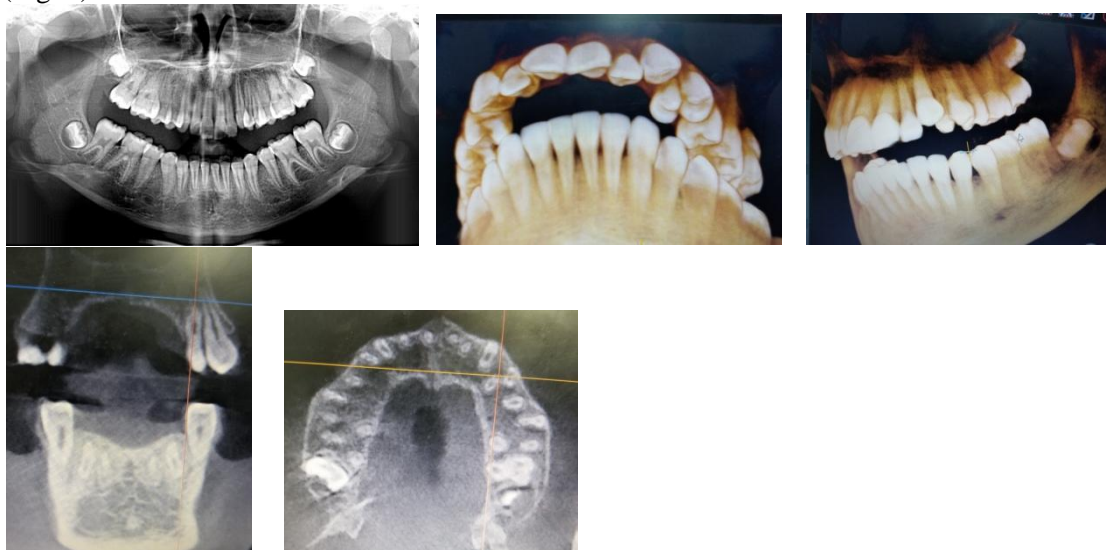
Orthopantomogram and 3D radiograph of the patient
